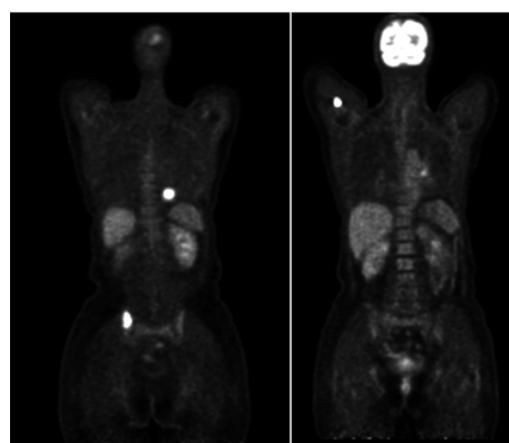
11: MIP appearance on the FDGPET/CT, highlighting the area of increased uptake on the right iliac bone and right humeral bone.
